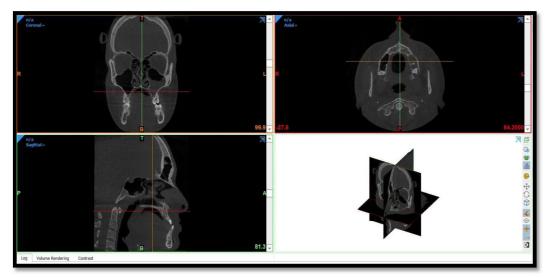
CBCT images of the maxilla used for the study.
